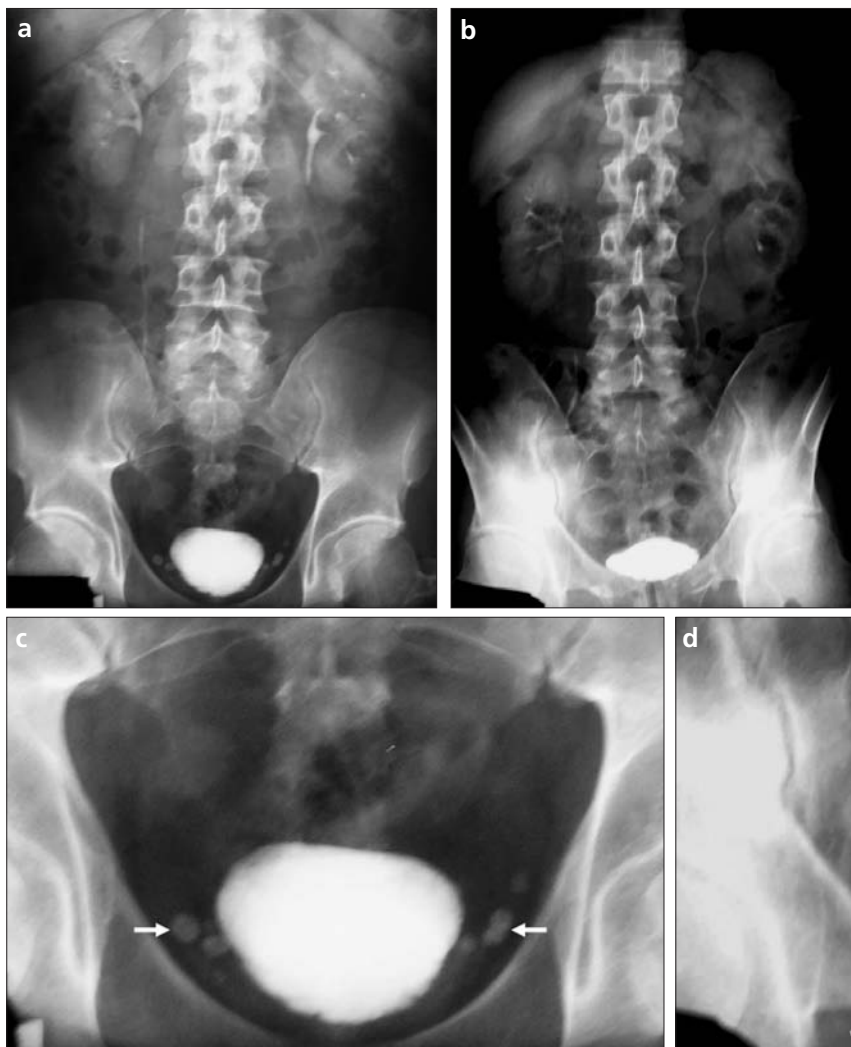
a–d. Ascertaining diagnosis of phleboliths. On kidney-ureter-bladder (KUB) radiographs (a–d), there are opacities in the small pelvis adjacent to the bladder with central lucencies, which strongly indicate phleboliths (white arrows). On supine KUB radiographs (a, c), their locations are suspicious for distal ureterolithiasis. On the upright KUB radiographs (b, d); it can be determined that those opacities (white arrows) are located outside the ureters (black arrow); note bilateral emptying of the pelvic calyceal systems with the upright positioning (b).
